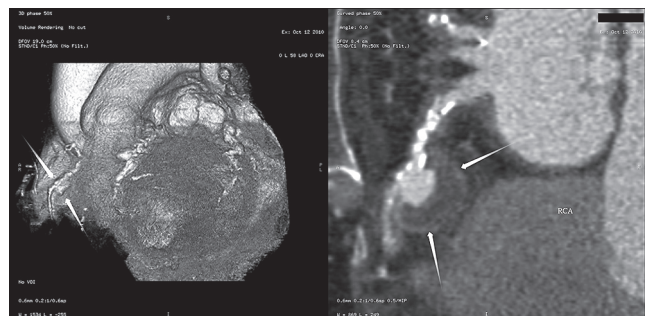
Multislice CT scan of the heart. Volume rendering (VR) image and curved multiplanar reformatted image demonstrating an aneurysm of the RCA (yellow arrows) with white spots reflect calcified atherosclerotic plaques.
